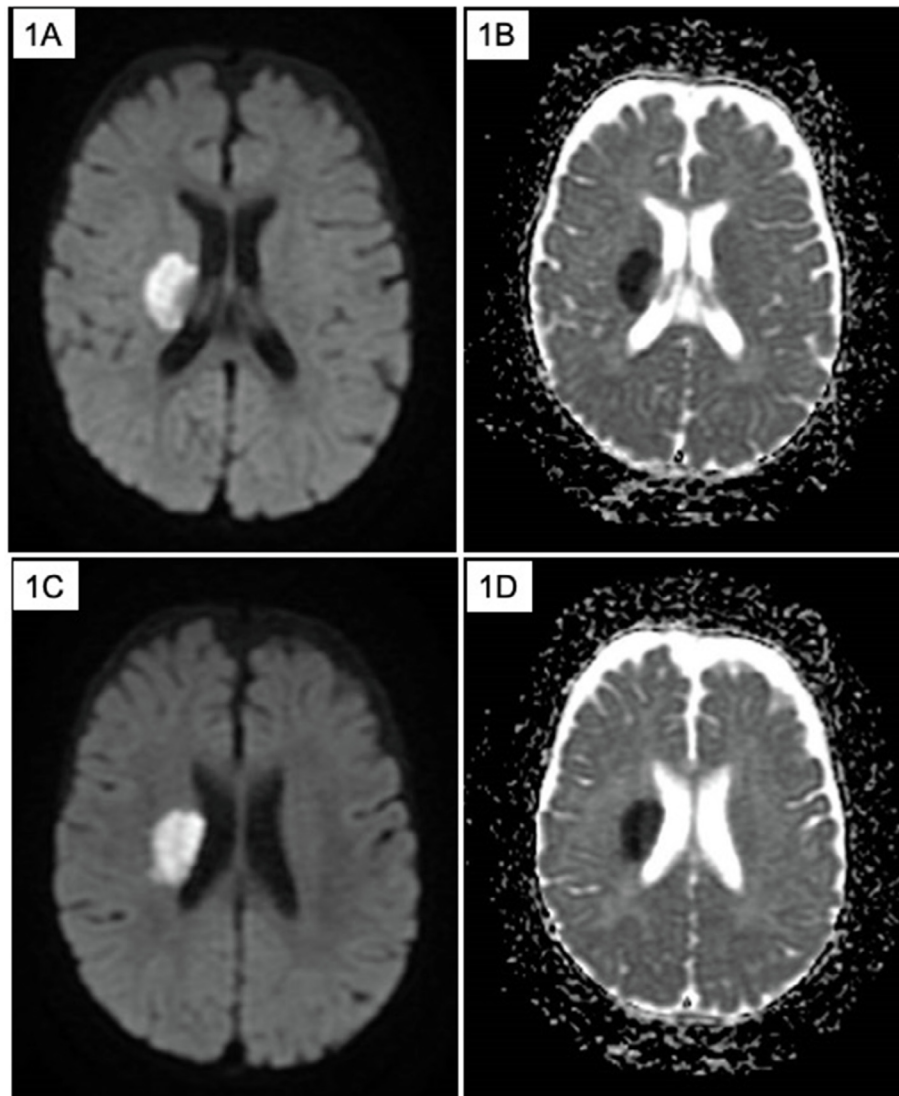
Representative axial DWI (diffusion-weighted imaging) and corresponding ADC (apparent diffusion coefficient) MRI images showing an acute infarct involving the right lentiform nucleus (1A and 1B) and corona radiata (1C and 1D).
